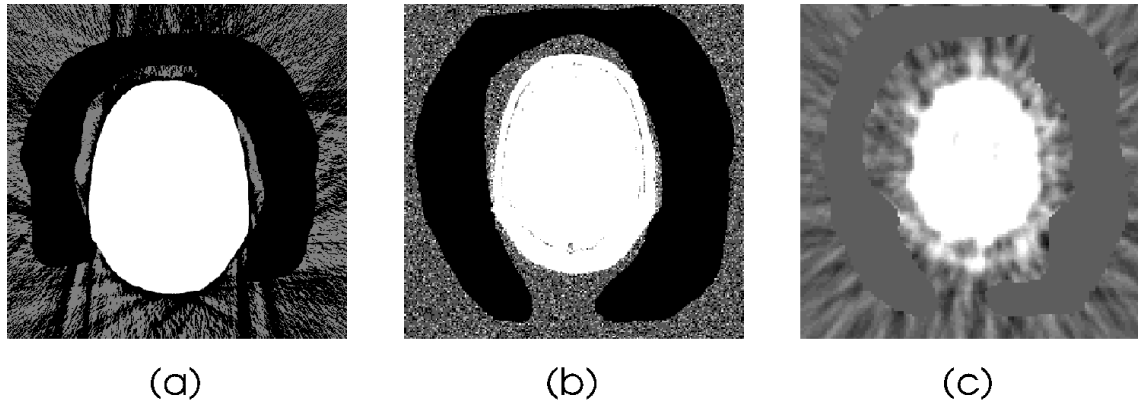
Image volumes after extraction of the region R : (a) CT, (b) MR, and (c) PET. Note that all trace of the stereotactic frame and fiducial markers has been removed.
